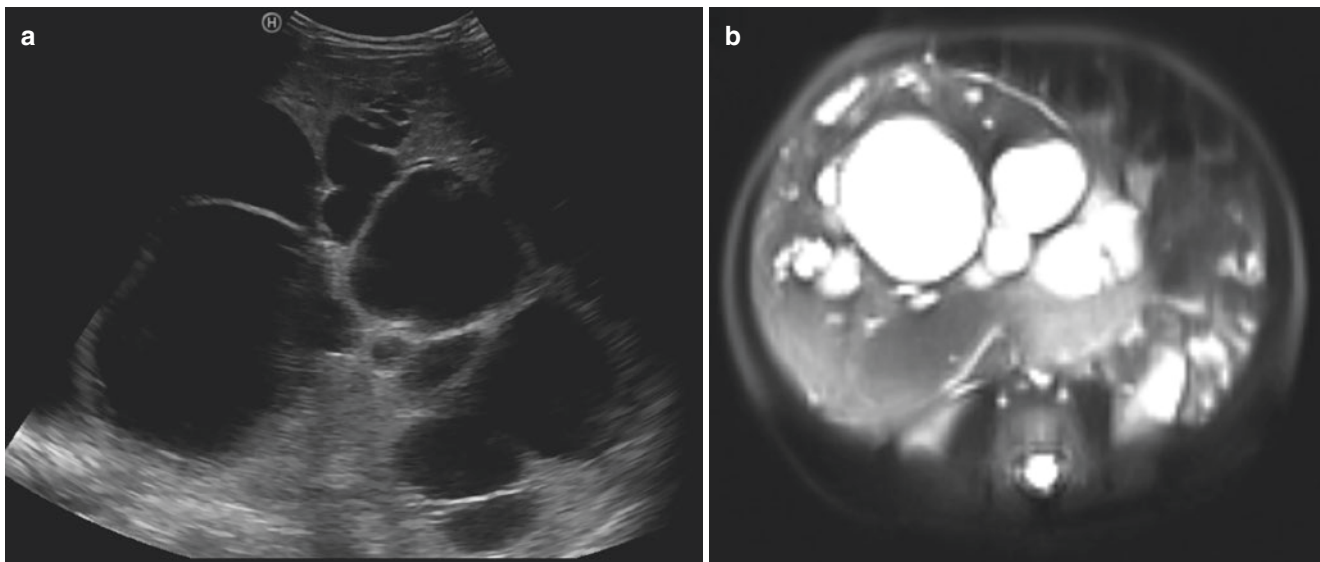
(a) US shows a multicystic mass with anechoic cysts and thin intervening septa. (b) A T2W MR image shows the lesion with multiple hyperintense cysts
